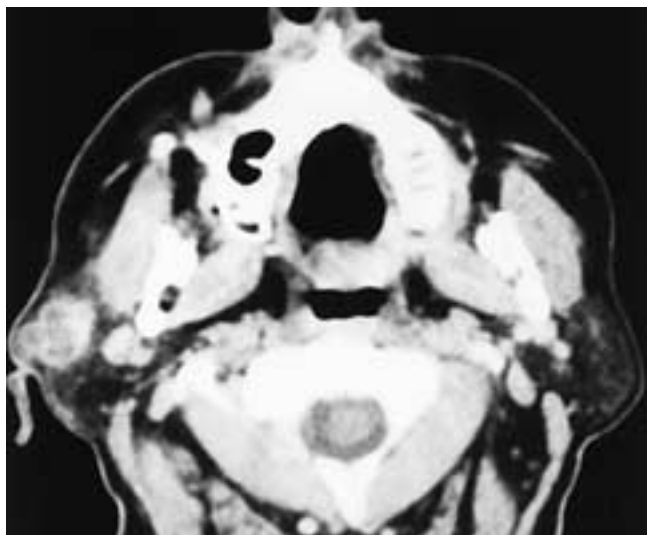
Axial CT scan shows a nodule in the right parotid gland. The mass has cystic areas within it, and the medial wall of the lesion is nodular and slightly unsharp as it merges with the adjacent parotid gland. This patient had a low-grade MEC.
